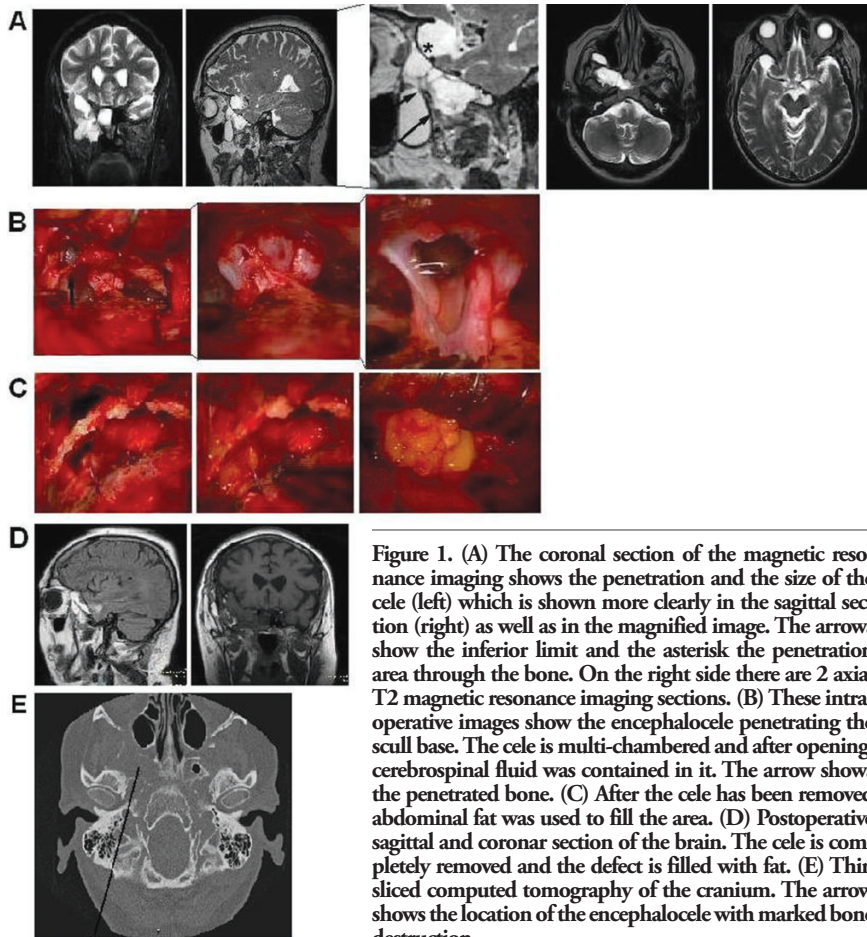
(A) The coronal section of the magnetic resonance imaging shows the penetration and the size of the cele (left) which is shown more clearly in the sagittal section (right) as well as in the magnified image. The arrows show the inferior limit and the asterisk the penetration area through the bone. On the right side there are 2 axial T2 magnetic resonance imaging sections. (B) These intraoperative images show the encephalocele penetrating the skull base. The cele is multi-chambered and after opening, cerebrospinal fluid was contained in it. The arrow shows the penetrated bone. (C) After the cele has been removed abdominal fat was used to fill the area. (D) Postoperative sagittal and coronar section of the brain. The cele is completely removed and the defect is filled with fat. (E) Thin sliced computed tomography of the cranium. The arrow shows the location of the encephalocele with marked bone destruction.
